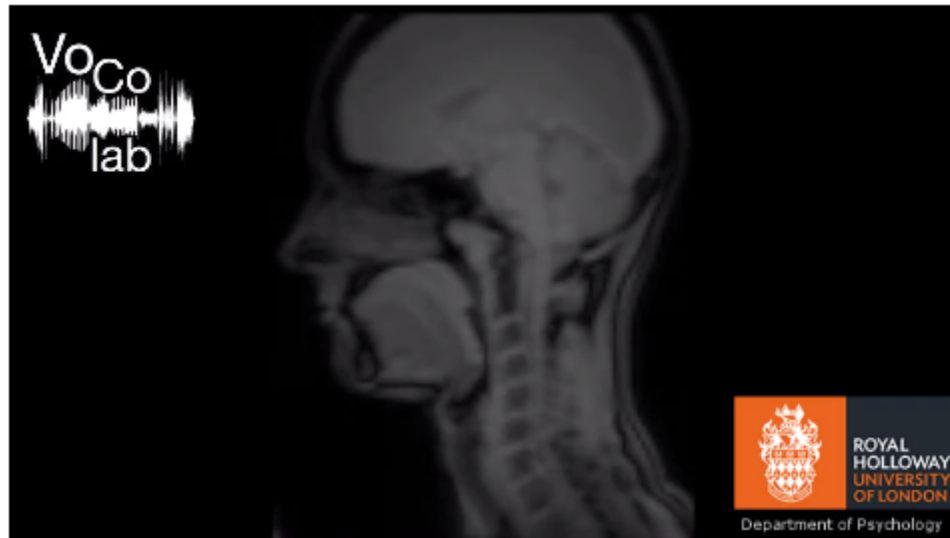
MRI capture of the lip-synch of Adele song *Hello*. Royal Holloway Vocal Communication Laboratory.
